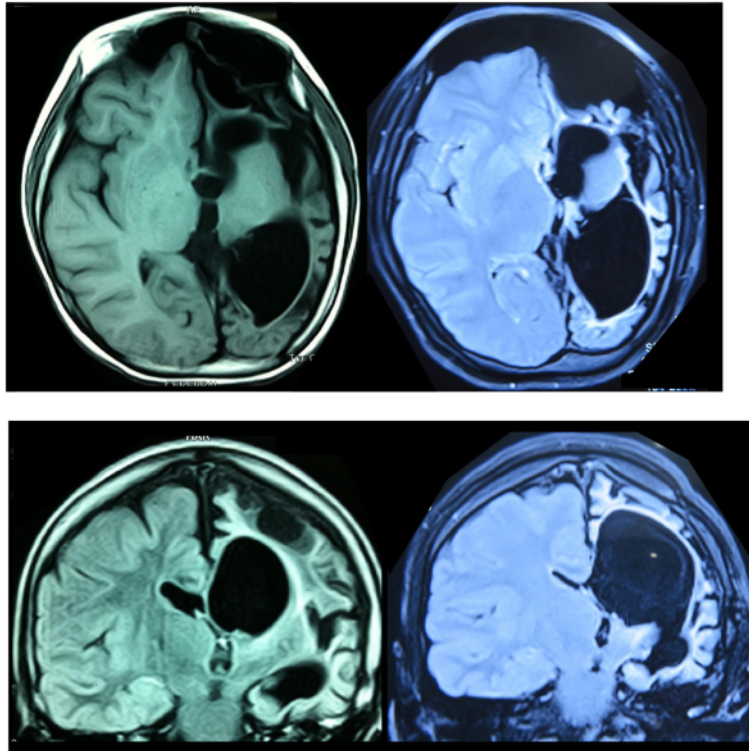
Preoperative (left) and postoperative (right) axial and coronal MRI slices of a 14-year-old female (Pt. no. 10) with right-sided infantile hemiparesis showed large porencephalic cysts in her left hemisphere. Left-sided hemispherotomy was performed (PIH). Postoperative observation resulted in complete seizure freedom (Engel class I) at 98 months.
